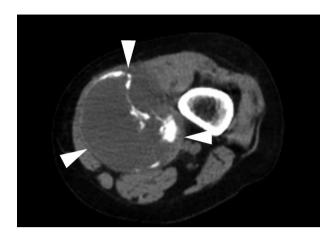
Computed tomography of the left distal thigh. A well-demarcated mass (arrowheads) within muscle with heterogeneous density and calcification.
